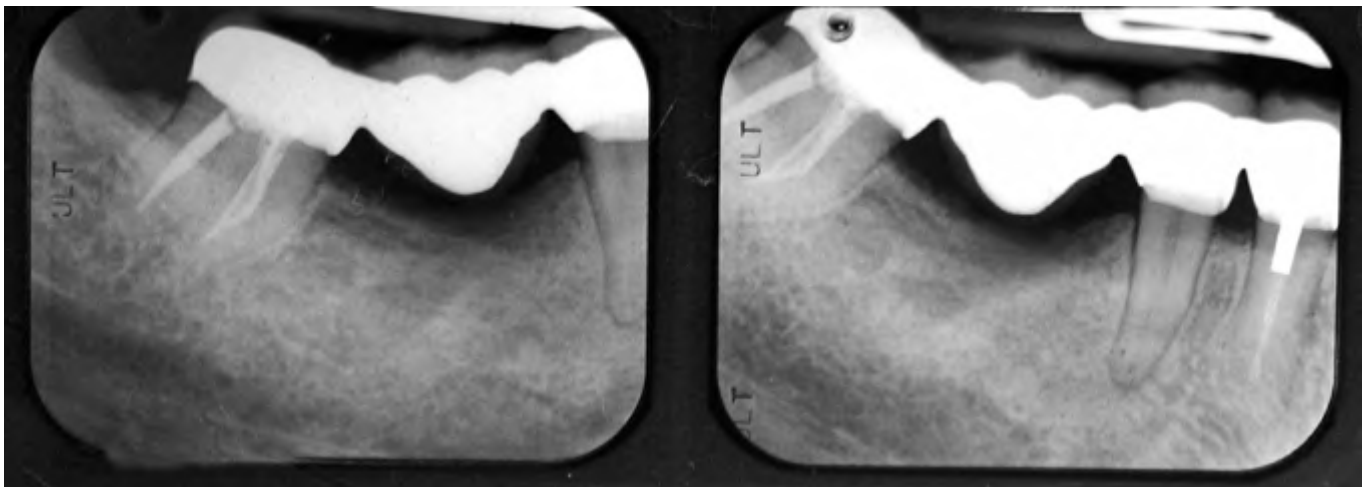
Two periapical radiographs of the teeth and preexisting FPD in the mandibular right posterior quadrant. The distal caries, widened periodontal ligament space, and previous endodontic treatment with a post in the canal space are evident in the mandibular second molar, second premolar, and first premolar, respectively.
